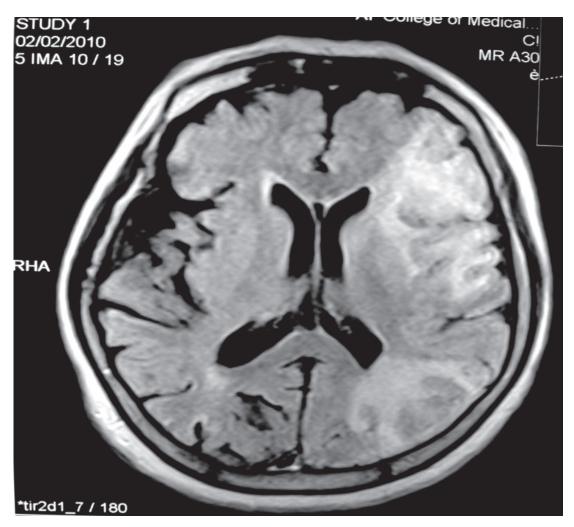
MRI brain of Patient 3 showing multiple infarcts in left opercular, posterior parietal, occipital and right parietal region. Marked atrophy of sylvian cortex (arrow) was noted on right side.
